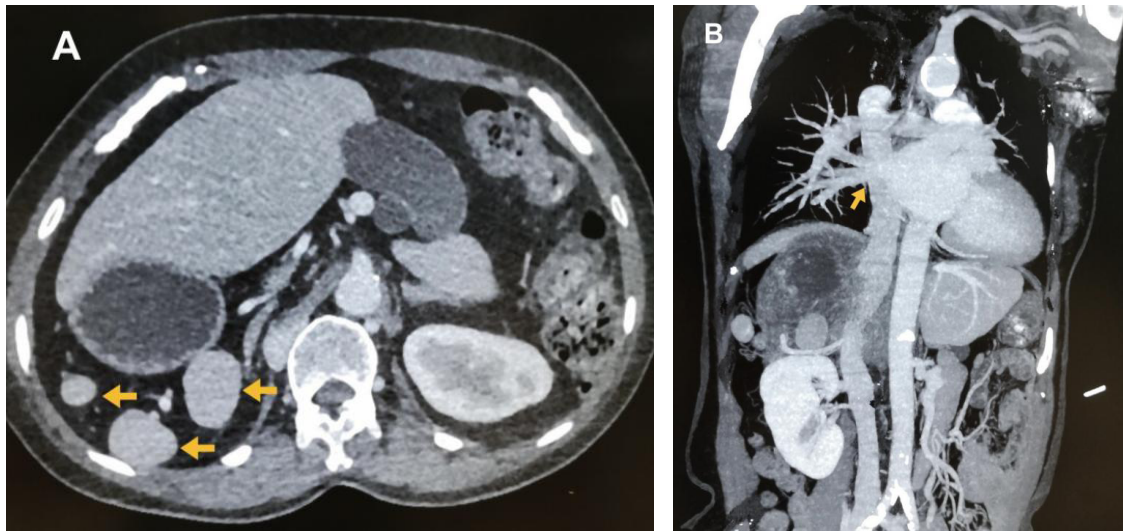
Enhanced CT examination of the thorax and abdomen in the patient. (A) Visceral abnormalities were observed, with the stomach and spleen located in the right upper abdominal cavity, and the liver and gallbladder converted into a midline-type liver. The orange arrows represent multiple spleens without a dominant spleen. (B) Cardiac abnormalities were observed, with the inferior vena cava absent. The orange arrows indicate the continuation of the giant malformed azygos vein behind the atrium into the superior vena cava.
